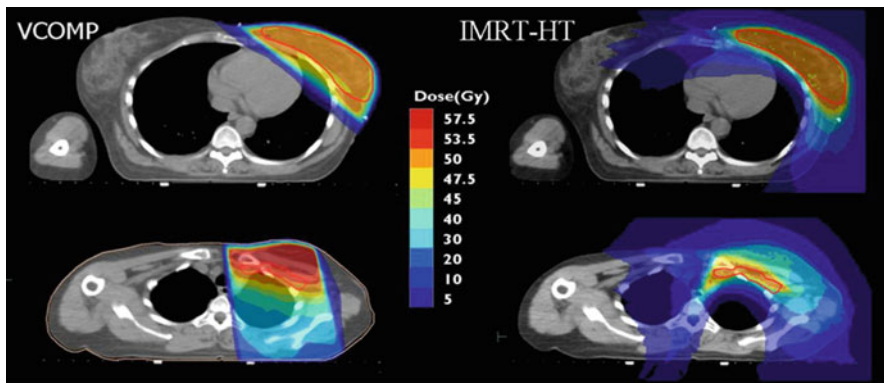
Dose distributions of VCOMP plan (left) and IMRT-HT plan (right) for the same patient and CT image. With the IMRT-HT plan, the high-level isodoses are highly conformal to the target volume and spare the lungs and heart, but a larger volume of normal tissue receiving low radiation dose, (between 5 and 10 Gy) is observed [17]
